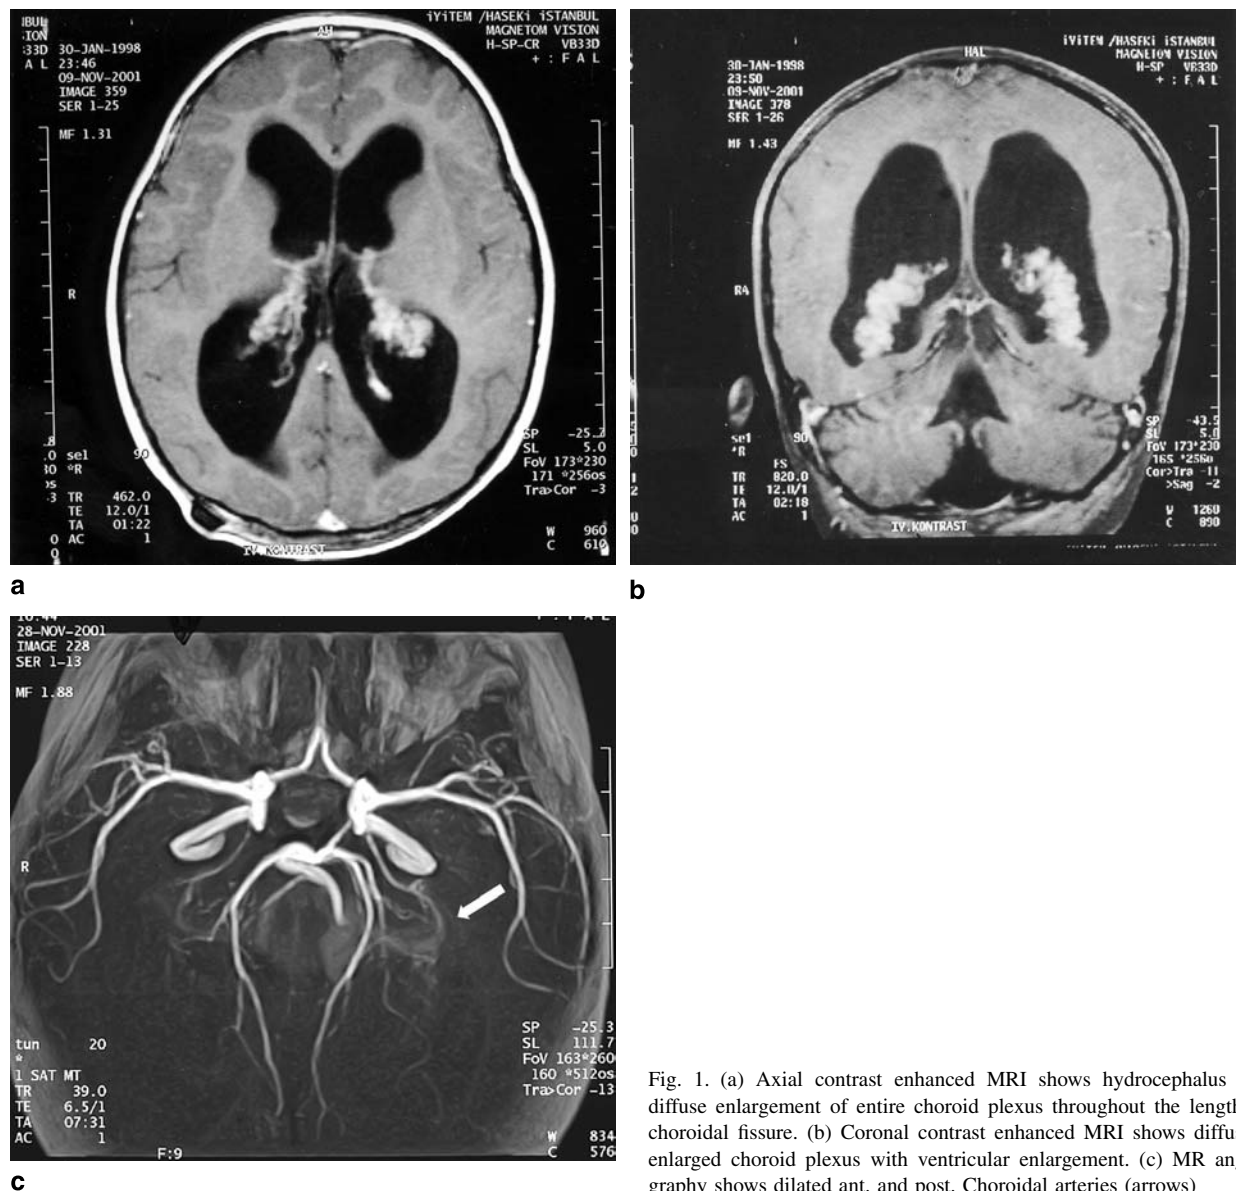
(a) Axial contrast enhanced MRI shows hydrocephalus and diffuse enlargement of entire choroid plexus throughout the length of choroidal fissure. (b) Coronal contrast enhanced MRI shows diffusely enlarged choroid plexus with ventricular enlargement. (c) MR angiography shows dilated ant. and post. Choroidal arteries (arrows)
